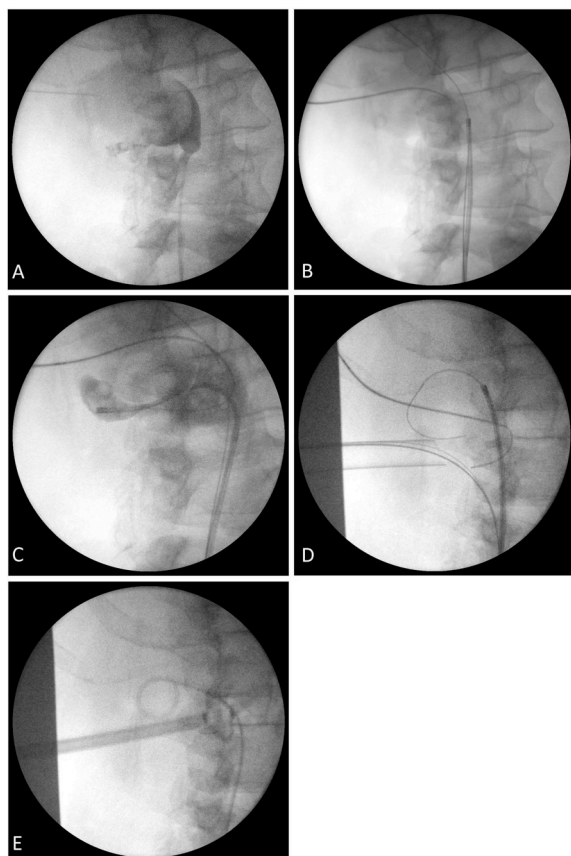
Intra-operative Image Intensifier Radiographs
